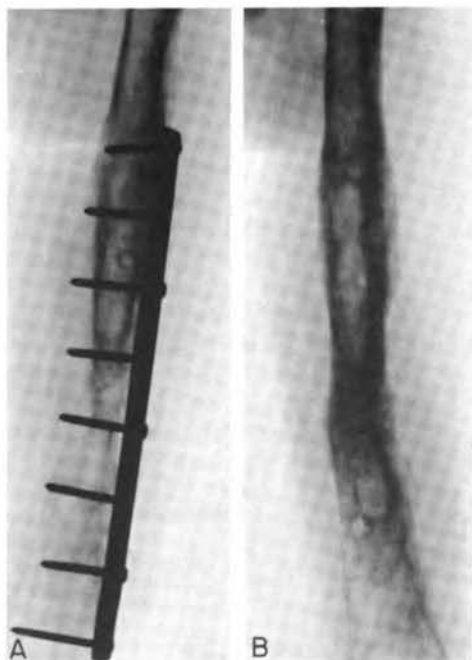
Case 3. A, femoral malunion and osteomyelitis at fracture site (November 1964). B, x-ray appearance of femur 4 months later (May 1965) after OHP treatment, demonstrating complete bone union and healing.
